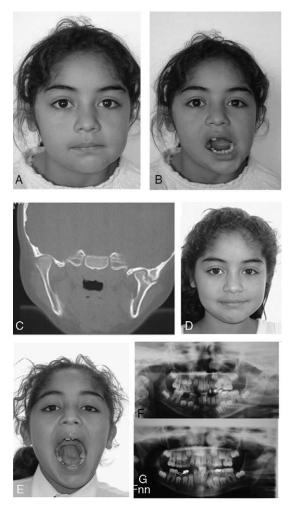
(A) Frontal view before surgery. (B) Maximum mouth opening before surgery. (C) Computed tomography scan of external TMJ ankyloses. (D) Frontal view after GAP arthroplasty (3 years after surgery). (E) Maximum mouth opening after GAP arthroplasty (3 years after surgery). (F) Panoramic x-ray of left external TMJ ankylosis before surgery. (G) Panoramic x-ray 3 years after GAP arthroplasty (patient 10). TMJ, temporomandibular joint.
